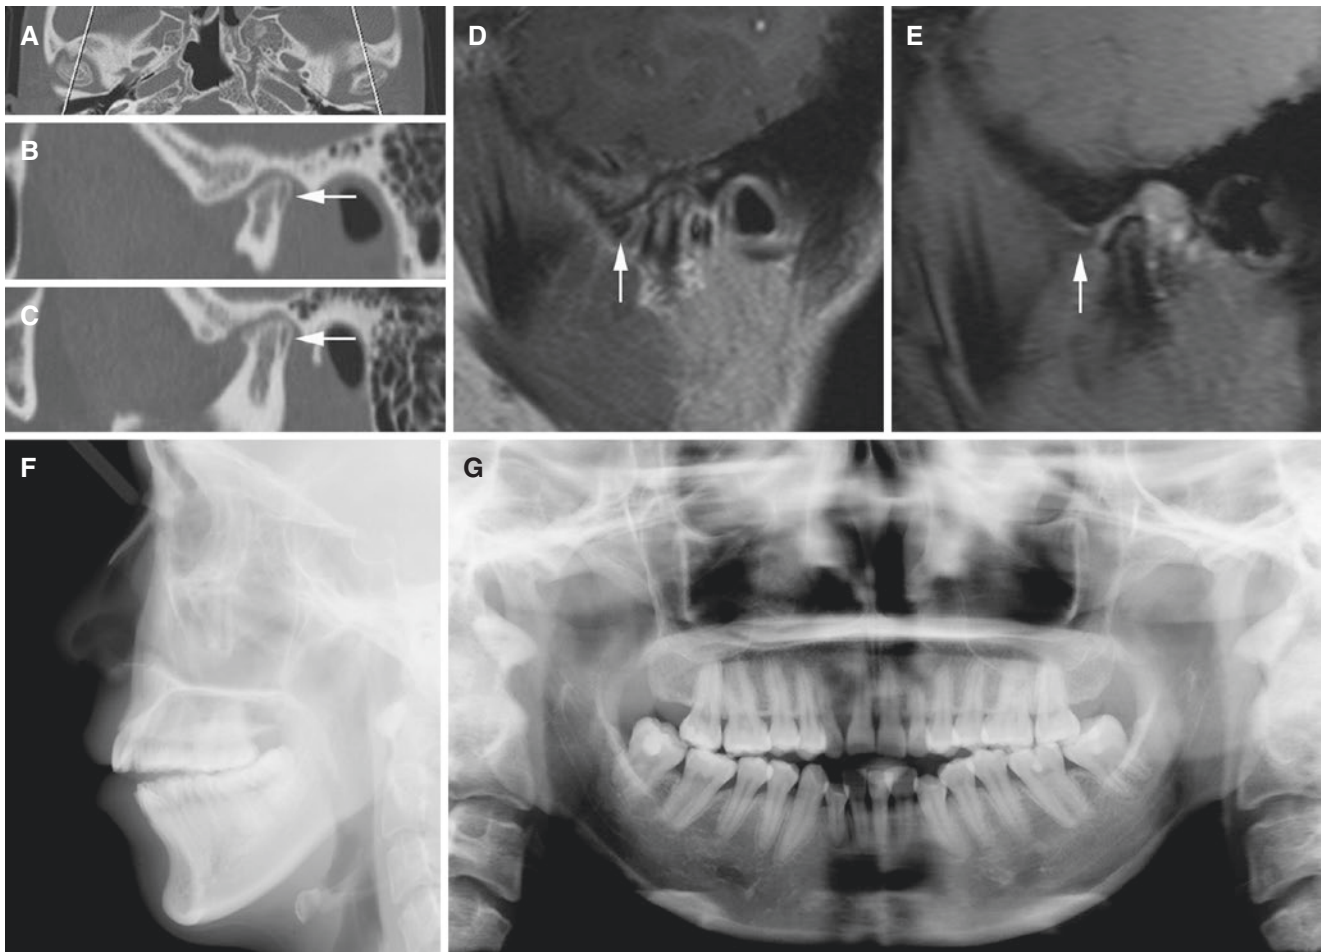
Juvenile osteoarthritis; 21-year-old female with long history of discomfort with dental occlusion (open bite). (A) Axial CT (with cursor lines), (B) oblique sagittal CT of the left joint, and (C) oblique sagittal CT of the right joint show remodeled condyles (flattened with posterior bone apposition) (arrow). (D) Oblique sagittal closed-mouth
